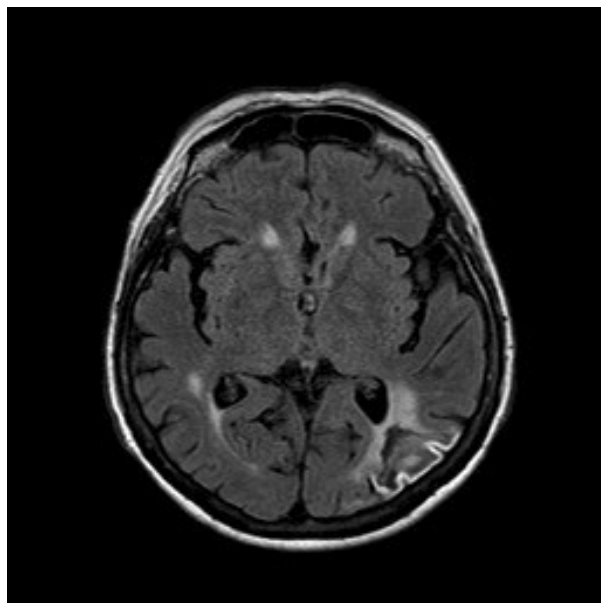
Patient no. 3 - FLAIR sequence showing post-ischemic encephalomalacia in the right temporo-occipital cortex.
